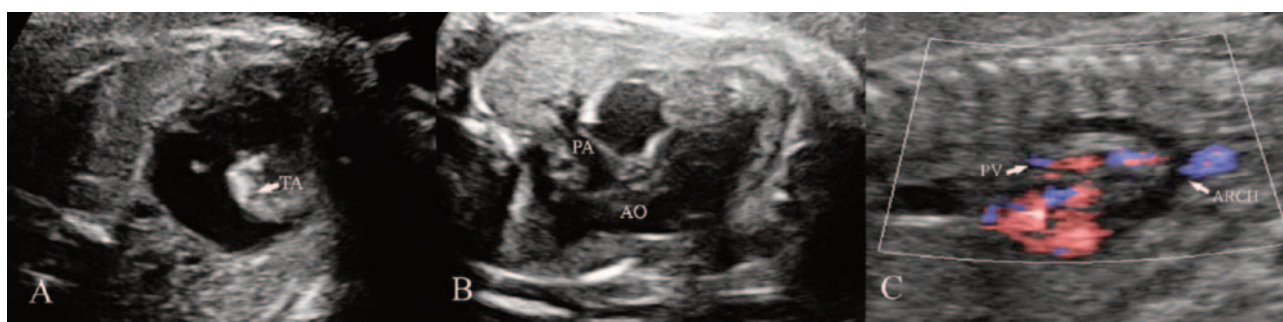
Fetal echocardiography diagnostic results of one fetus at the gestational age of 29 weeks (total anomalous pulmonary venous drainage (supracardiac type), functional single atrium (right heart auricle isomerism), right atrioventricular valvular closure, single ventricle, pulmonary artery atresia, and right aortic arch complicated with vascular ring formation). A: The four chamber plane does not show high-level echoes other than one muscular strong echo from the tricuspid valve area (the tricuspid valvular closure is indicated by the arrow); B: the five chamber plane shows the aorta located on the right side of the pulmonary artery (right transposition of the great arteries) and the closure at the pulmonary artery opening; and C: The plane of the long axis of the aortic arch shows the abouchement of the pulmonary veins into the superior vena cava. TA: tricuspid atresia; AO: the aorta; PA: the pulmonary artery; PV: pulmonary veins; and ARCH: the aortic arch.
